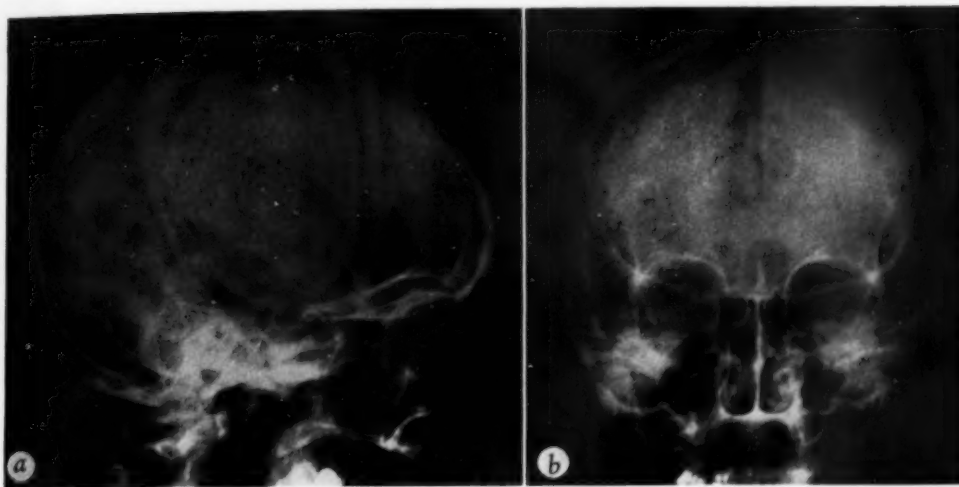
Intracranial lipoma. *a*. Lateral view of skull revealing curvilinear deposits of calcium in the peripheral portion of the tumor. The central portion is rarefied and less dense than surrounding structures. *b*. Postero-anterior roentgenogram revealing parasagittal situation of intracranial lipoma. The calcification in the periphery of the tumor and the central rarefaction due to the fat are well shown.
